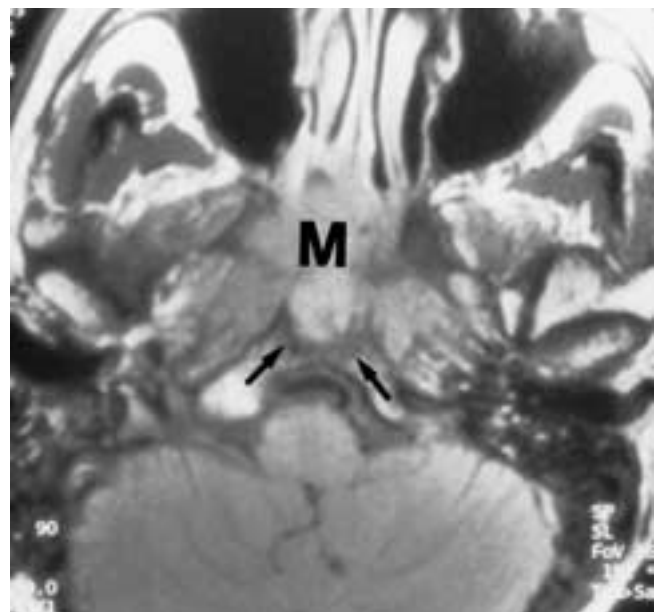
Axial noncontrast, T1-weighted image shows a nasopharyngeal carcinoma (*M*) extending into the clivus and replacing the normal increased T1-weighted signal (*arrows*). These findings are indicative of skull base erosion on MR imaging.
